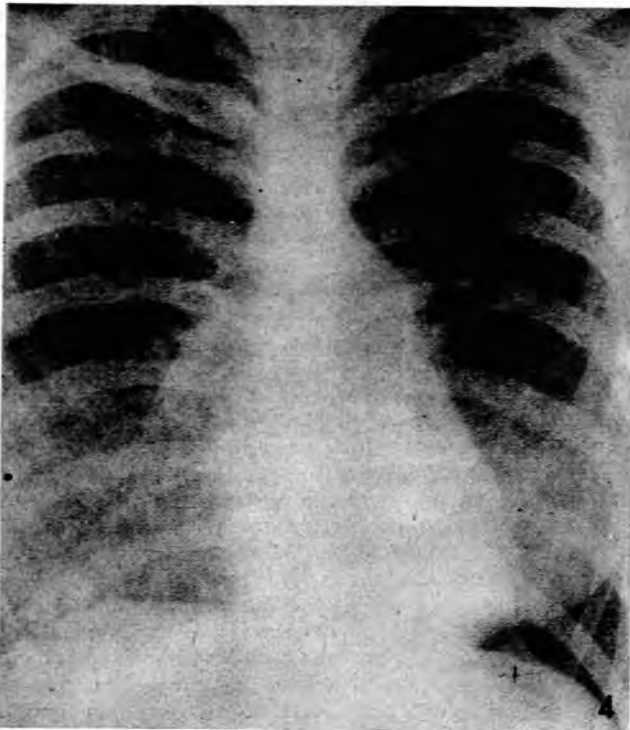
Radiograph showing minimal 'plethora' of the lungs.
